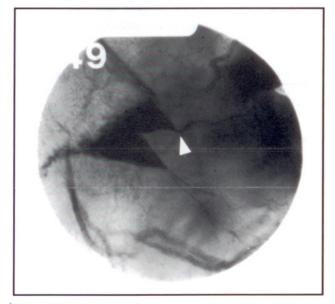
Modified dental x-ray generator projection of the right temporal region showing avulsed portion and associated fracture lines (arrow). These were not well visualised in the standard medical x-ray projections.
